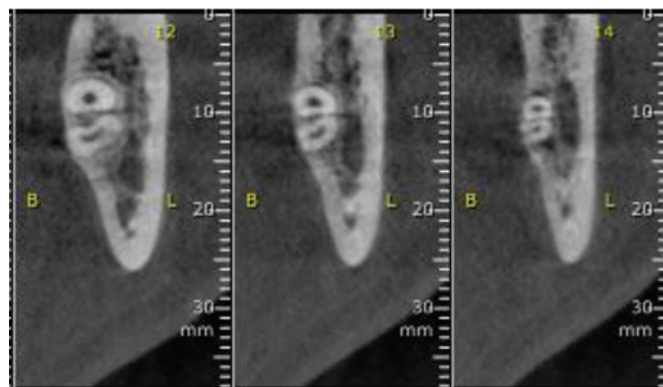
CBCT sections indicating the left lower third molar roots in contact with mandibular canal
